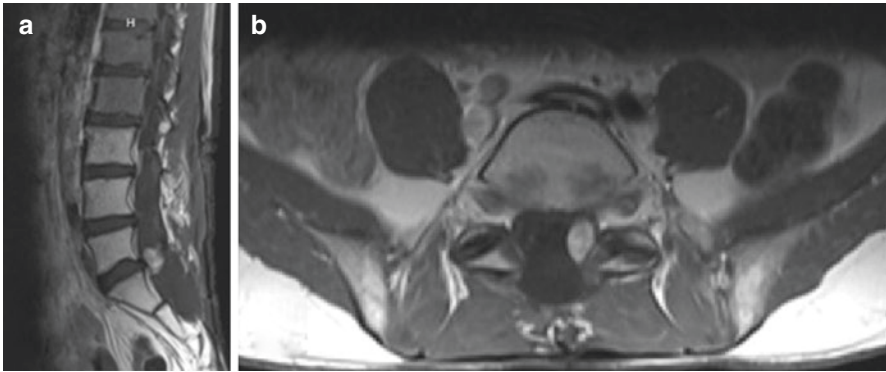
Sagittal (a) and axial (b) MRI showing radiographic stability 7 years post-radiation, which showed interval growth
